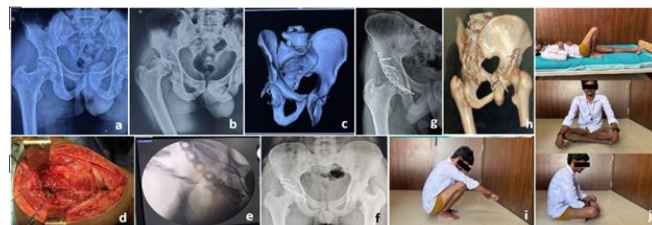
(a–c) Preoperative X-rays and CT images showing a right posterior acetabular wall fracture with posterior dislocation of the right hip. (d–e) Intraoperative images demonstrating posterior wall fracture and reconstruction plate fixation. (f) Immediate postoperative X-ray. (g–h) Postoperative X-rays and CT at 6-month follow-up. (i–j) Range of movement at 6 months.
